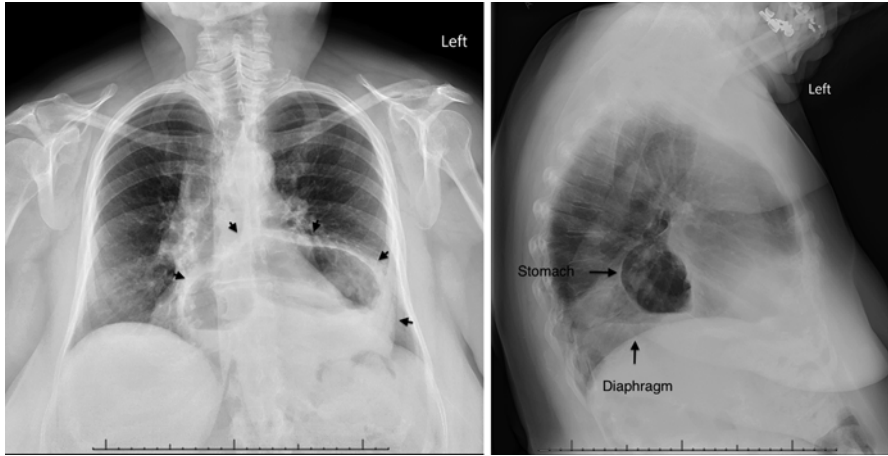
Chest x-ray. Paraesophageal hernia with stomach above the diaphragm (*short arrows*)
